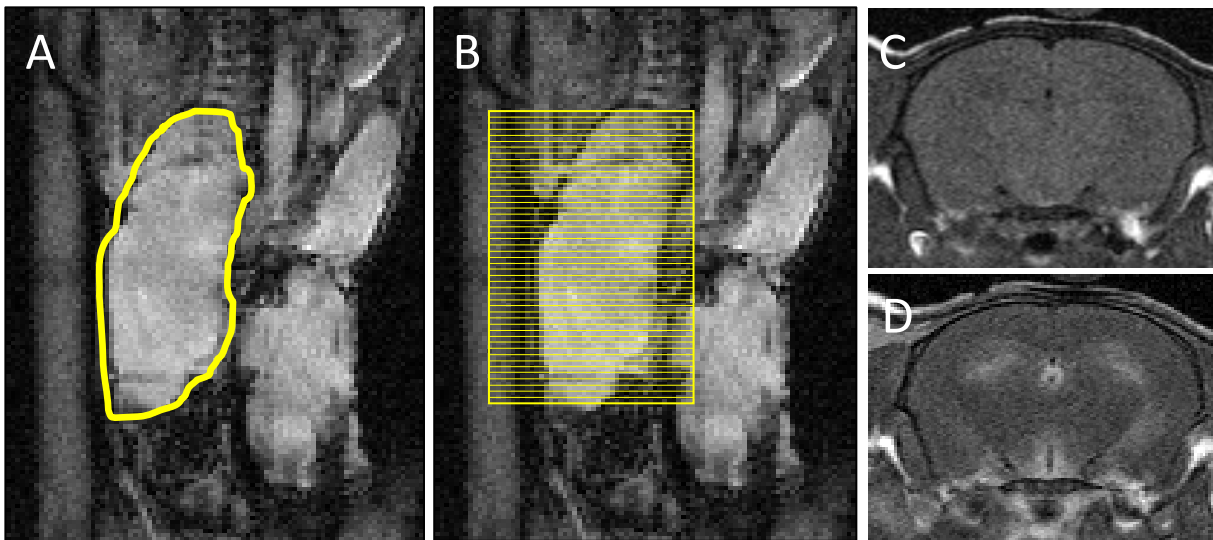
Planning of the axial MR images through the brain.
